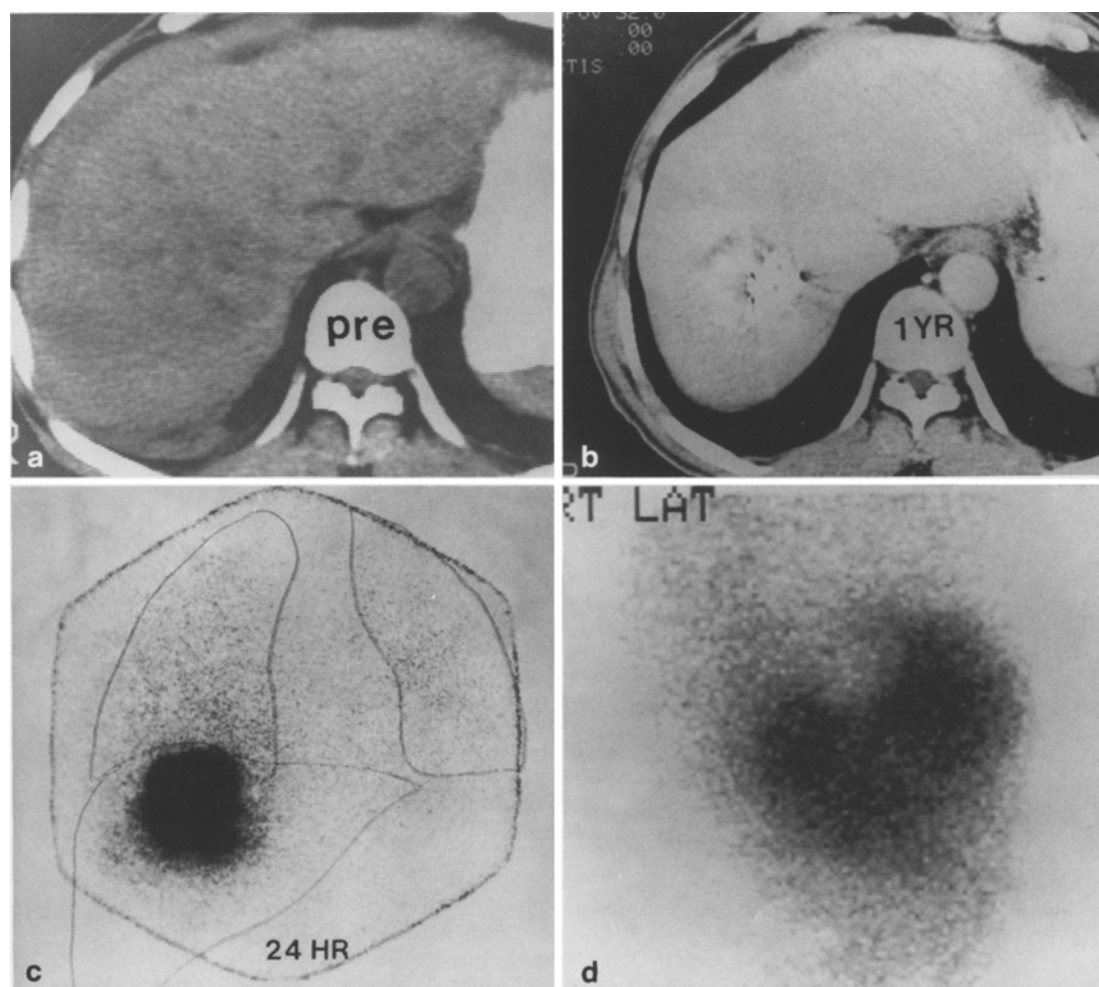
a Computed tomography (CT) scan reveals 6 cm low-density mass in right dome of liver, which was confirmed as hepatocellular carcinoma (HCC) on aspiration cytology. b High levels of radioactivity of [^{131}I]lipiodol are seen in the tumor and slight radioactivities are noted in both lungs. c One-year follow-up CT scan shows confined lipiodol density and marked contraction of tumor. d Twenty-one-month follow-up ^{67}Ga scan reveals unlabeled defect on tumor site suggestive of nonviability of HCC
